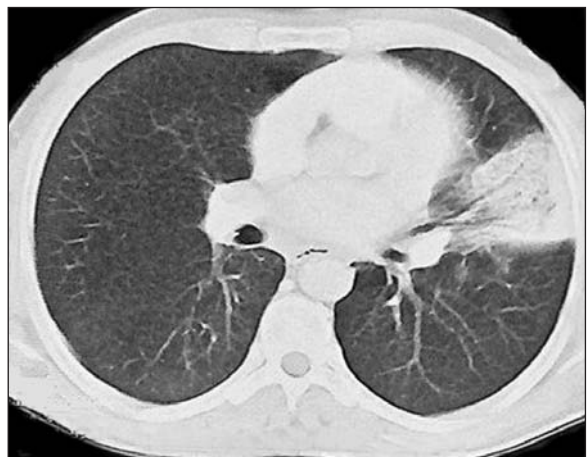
There is consolidation with air bronchogram in lingular segment in thorax computed tomography.
